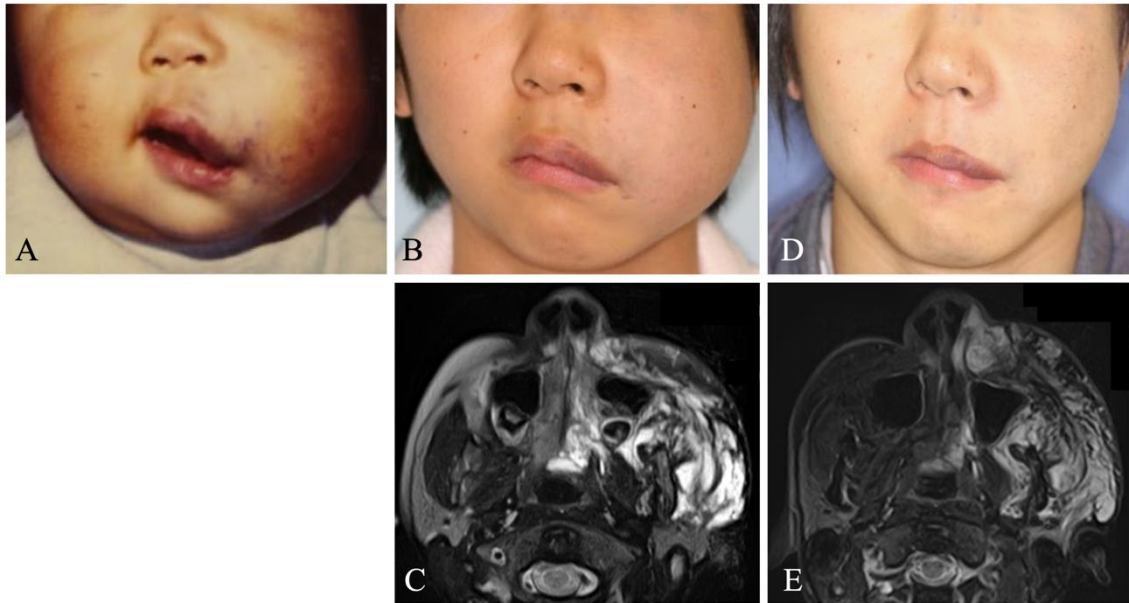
Patient 1 showed good effectiveness of treatment. (A) Initial clinical photograph of a 1-year-old boy with venous malformation in the left cheek. Sclerotherapy was started at the age of 4 years and consisted of 5 sessions of ethanol sclerotherapy followed by 18 sessions of polidocanol 1% sclerotherapy. Transient facial nerve paralysis of the buccal branch occurred at the 24th session of sclerotherapy, at which time 28 mL of ethanol was used. Since then, he has undergone sclerotherapy using ethanol and polidocanol 3% without any complications. (B) Clinical photograph and (C) fat-suppressed T2-weighted magnetic resonance image obtained at the age of 14 years after 26 sessions of sclerotherapy. (D) Clinical photograph and (E) short tau inversion recovery T2-weighted magnetic resonance image obtained at the age of 19 years after 32 sessions of sclerotherapy and operations including a facelift and partial resection of the lip lesion.
